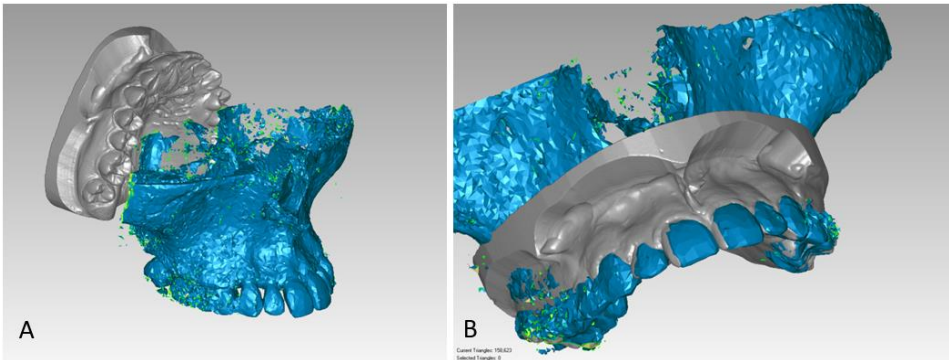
Merging of CBCT and digital dental arch. A) Before and B) after merging ⁶⁴.
